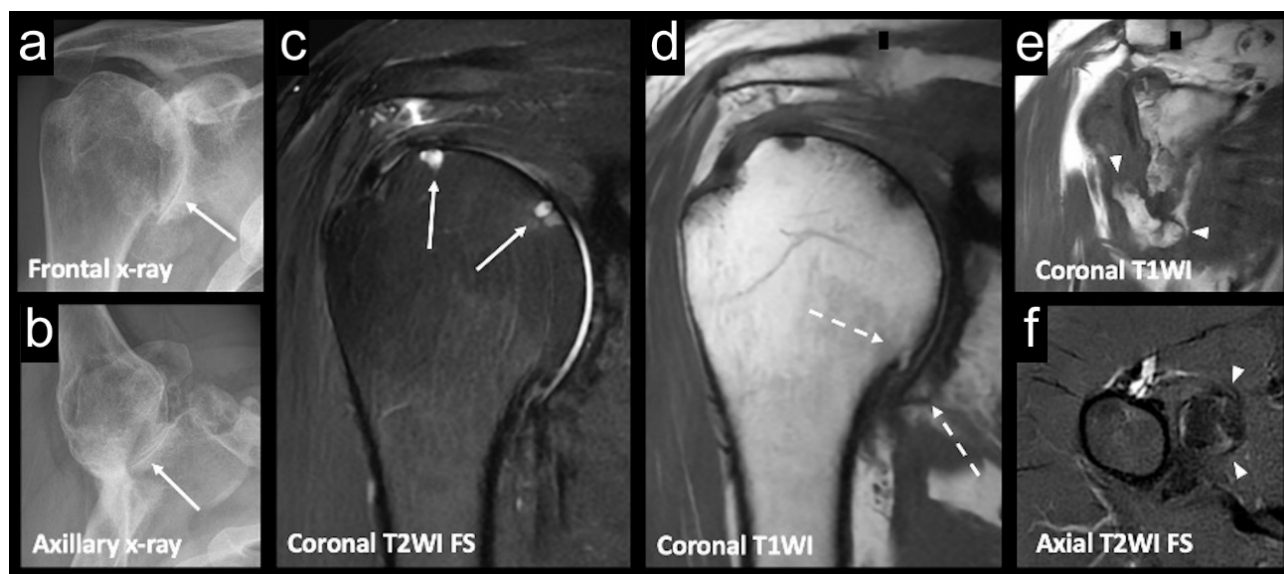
A 63-year-old male patient undergoing a post-traumatic MRI follow-up examination. (A,B) Frontal and axillary X-ray views showing joint space narrowing and bone remodeling, consistent with glenohumeral osteoarthritis. (C–F) MRI scans showing diffuse chondral thinning and reduced joint space, as well as areas of subchondral bone edema and cysts (arrows), together with marginal osteophytes (dashed arrows). Note the small glenohumeral joint effusion with a large, ossified intra-articular loose body (arrowhead).
